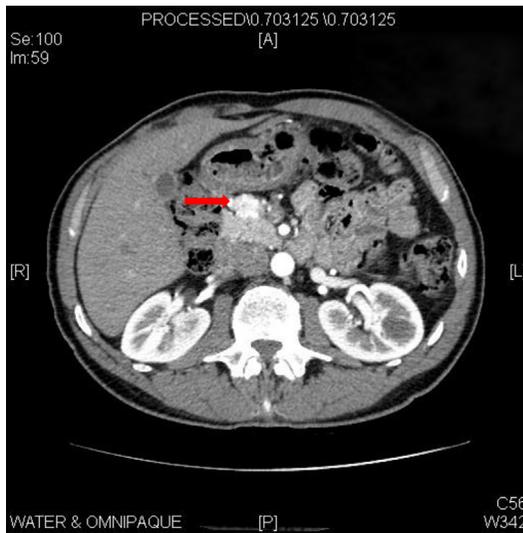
Contrast-enhanced CT scan of insulinoma in pancreatic head (*arrow*). Tumor demonstrates arterial enhancement and is thereby distinguished from the remaining pancreatic parenchyma.
